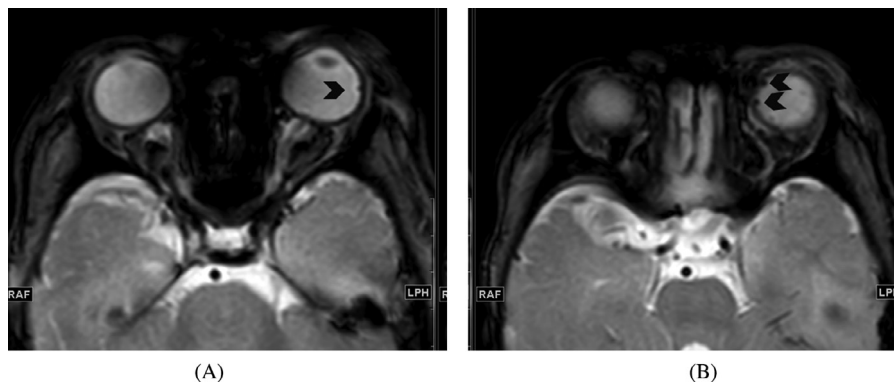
Retinal hemorrhages. (A and B) axial T2* images through the orbits from a brain MRI examination of a 7 months old (same patient as in Fig. 2) demonstrate left retinal hemorrhages (arrowheads). On fundoscopy patient had sever left retinal hemorrhages and no right retinal hemorrhages.
